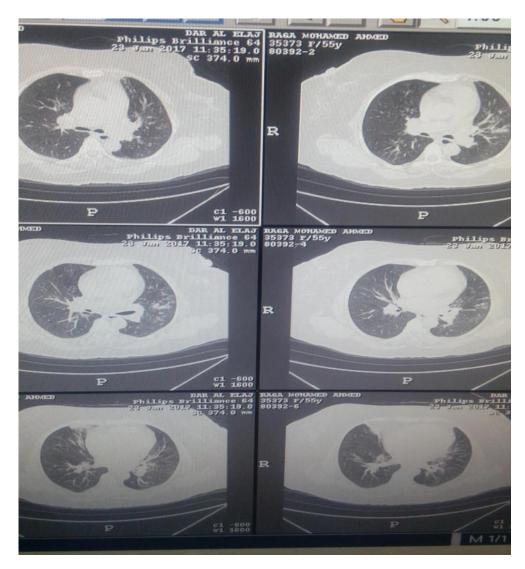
HRCT axial chest for female 55 years old show pneumonic consolidation.
